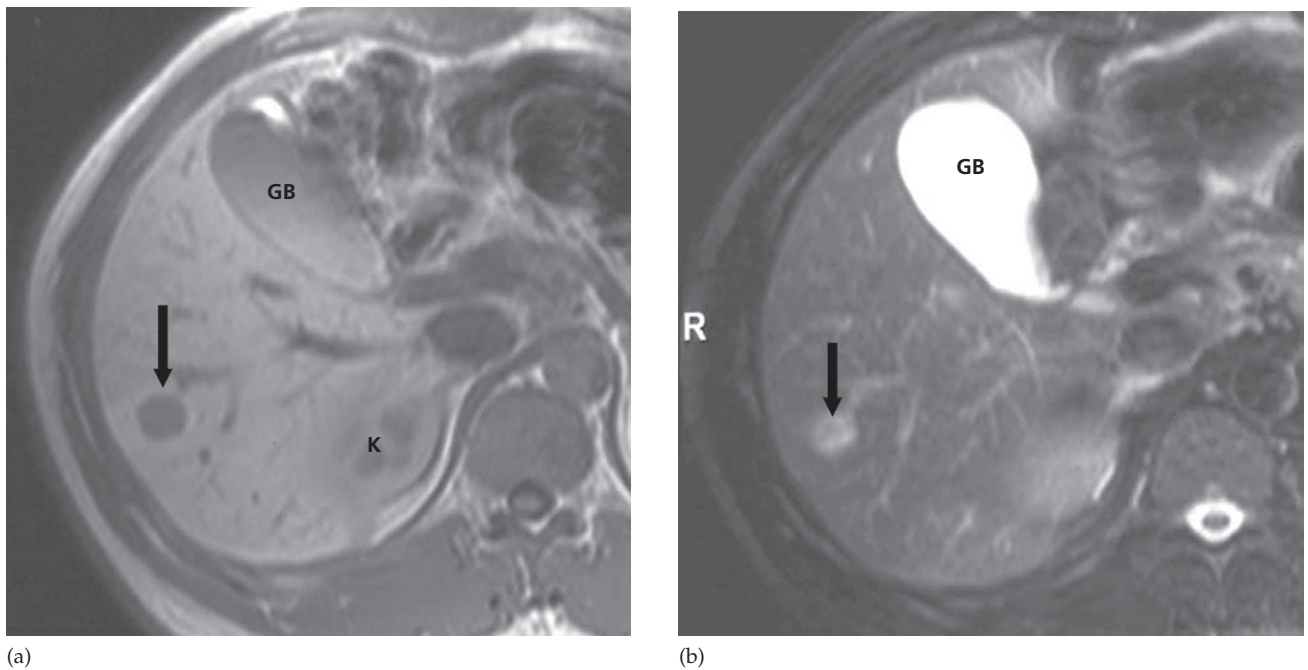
Liver metastasis on MRI. (a) T1-weighted MRI scan showing a solitary low signal intensity focus in the liver (arrow). (b) T2-weighted MRI (with fat saturation) showing the same metastasis. This is of higher signal intensity than the normal liver parenchyma; however, the signal intensity is not as bright as a haemangioma or cyst. GB, gall bladder; K, kidney.
